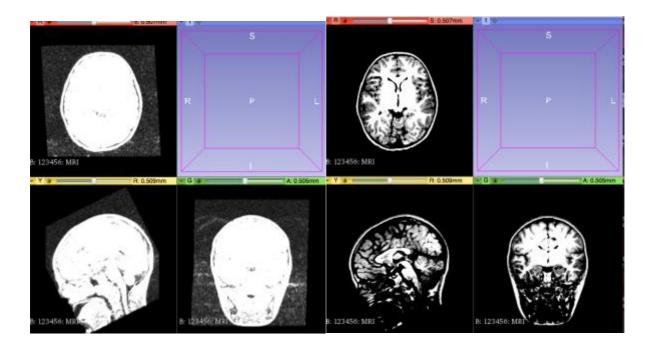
MRI scan without adjusting contrast(left), and with adjusted contrast (right) in 3D slicer
